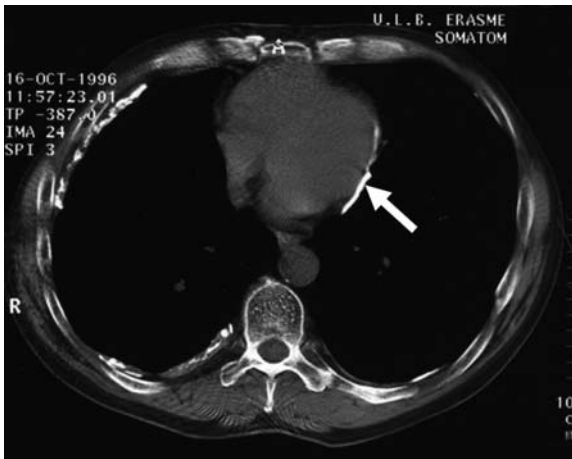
Computed tomography scan of the chest shows calcified pericardial thickening (arrow)
